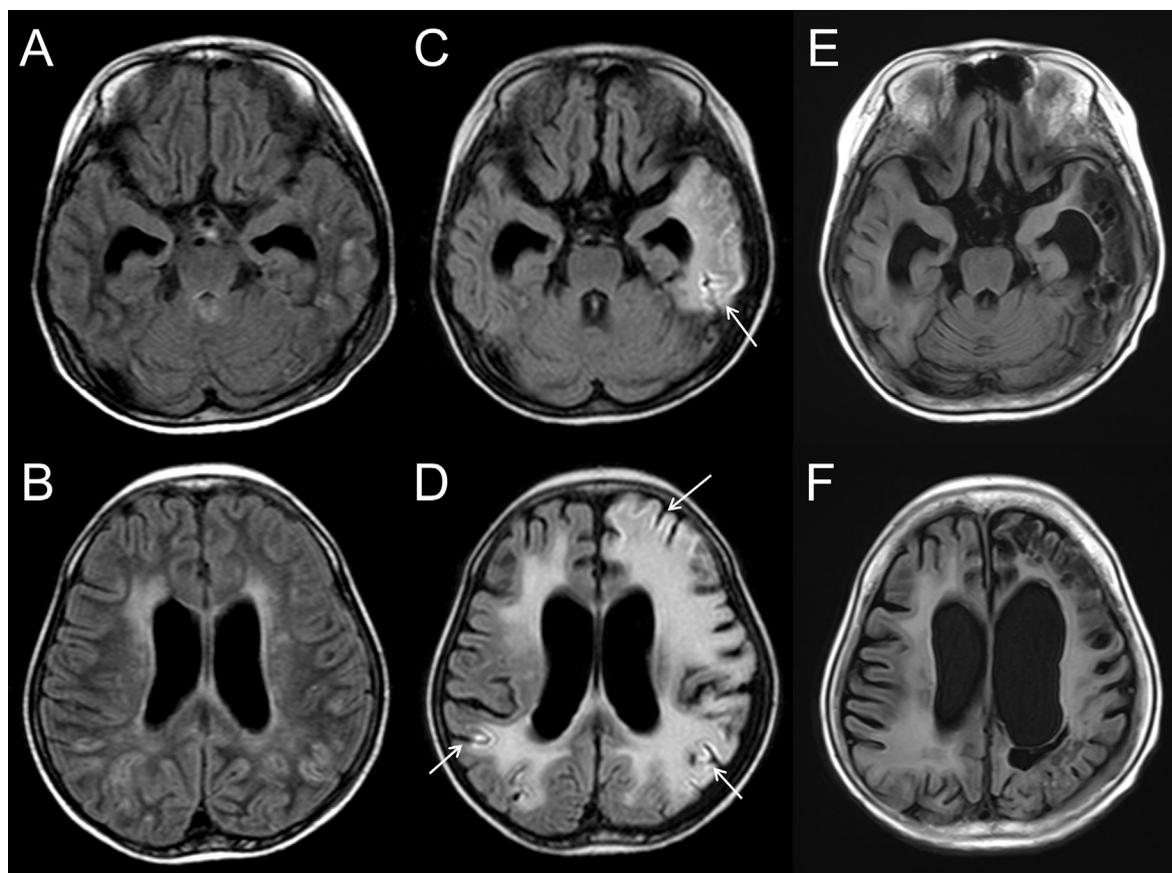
Axial unenhanced MR FLAIR imaging at 13 days (A and B), 3 months (laminar necrosis [arrows]) (C and D), 57 months (E and F) after the first relapse. Including Fig. 1, cerebral atrophy and cerebral structural disruption progress with time. In a typical case of limbic encephalitis, atrophy occurs in the mediotemporal lobes, and cerebral atrophy appears at several months (not just a few weeks) after the onset of encephalitis. Cerebral atrophy in this case is diffuse and started at only about two weeks after the onset of the first relapse.
